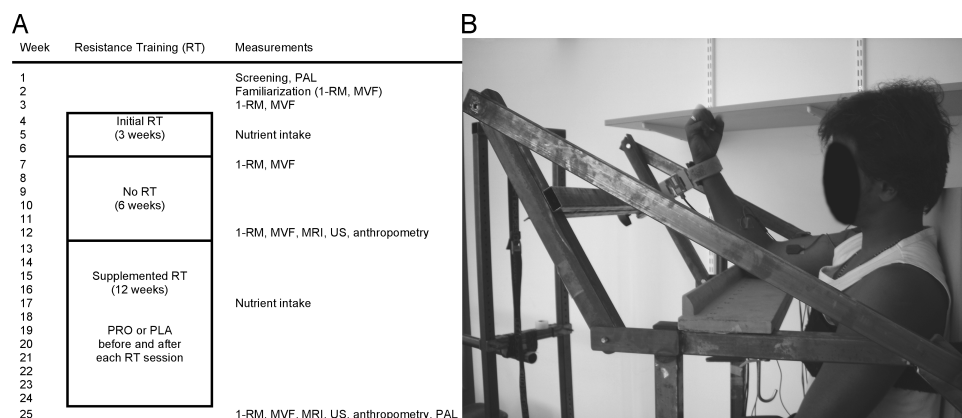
A. Overview of the study intervention periods and measurements: 1RM, 1-repetition maximum; MVF, isometric maximum voluntary force (including sEMG); MRI, magnetic resonance imaging to assess muscle size; US, ultrasound measurements of muscle architecture; anthropometry, skinfold measurements, body mass, and height; Nutrient intake, food and drink intake weighed and recorded over 3 d; PAL, physical activity level assessed via questionnaire. B. Isometric strength testing apparatus used to measure elbow flexion and extension MVF.
